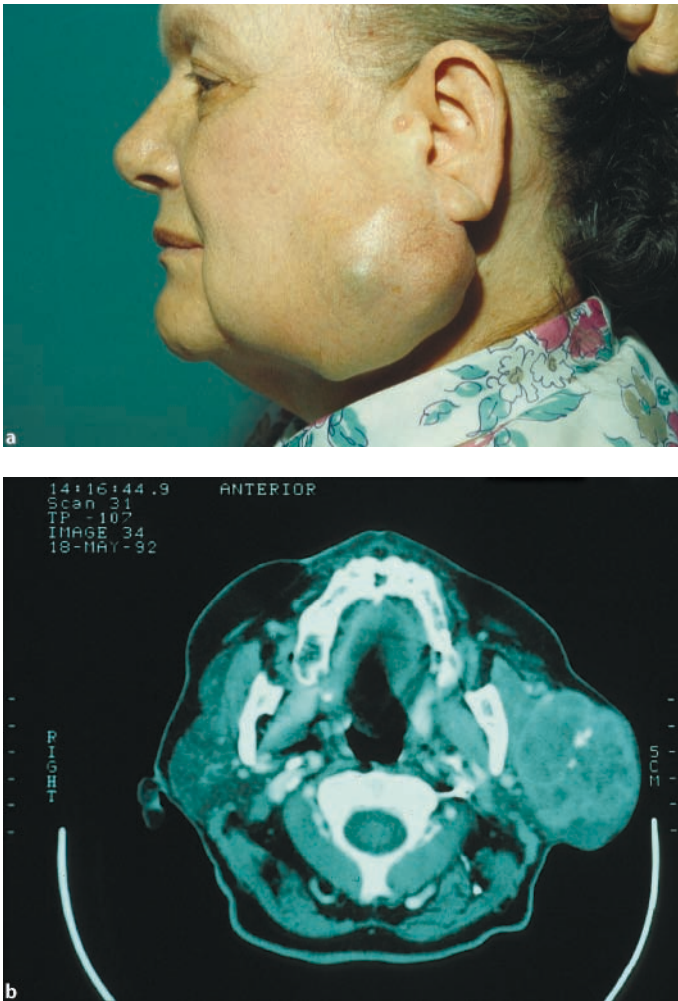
a A 65-year-old patient with a 20-year history of a 7×5 cm mass in the parotid gland with a recent history of rapid increase in size and pain. Parotidectomy revealed carcinoma ex-pleomorphic adenoma. The patient was treated with adjunctive postoperative radiotherapy, had local and regional control, but died of distant metastasis within two years. b CT scan of same patient with carcinoma ex-pleomorphic adenoma
